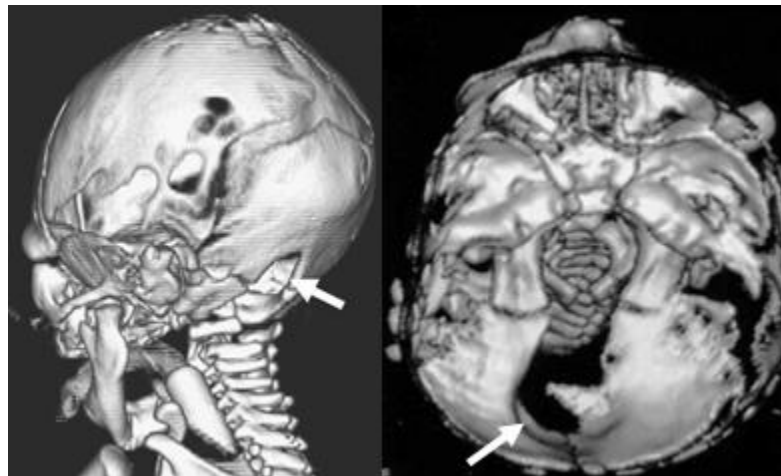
3-D rendering of CT scan images. Left image shows occipital deformation due to an occipital encephalocele (adapted from Smith et al. 2007: 1037). Right image shows a cranial cleft extending from the occipital to the foramen magnum (adapted from Kita et al. 2002: 355).
